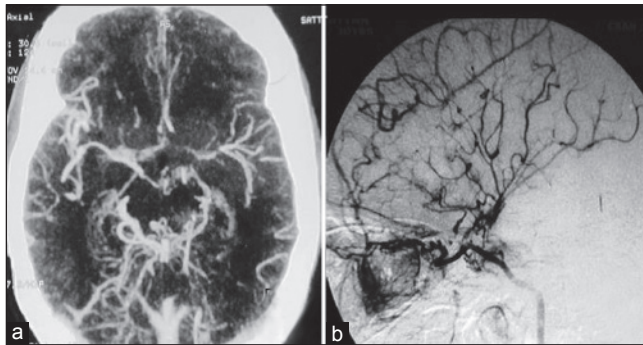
(a) Computed tomography (CT) head showing ICH with IVE. (b) CT angiography showing bilateral prominent basal collaterals. (c) DSA (right ICA injection) showing puff of smoke appearance at distal ICA and proximal MCA. ICH = Intracerebral hemorrhage, IVE = intraventricular extension, DSA = digital subtraction angiography, ICA = internal carotid artery, MCA = middle cerebral artery
